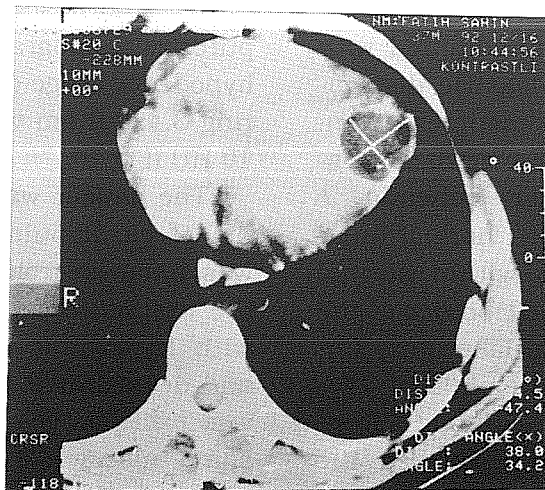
CT-image of the heart showing hypodense apical bulge.
